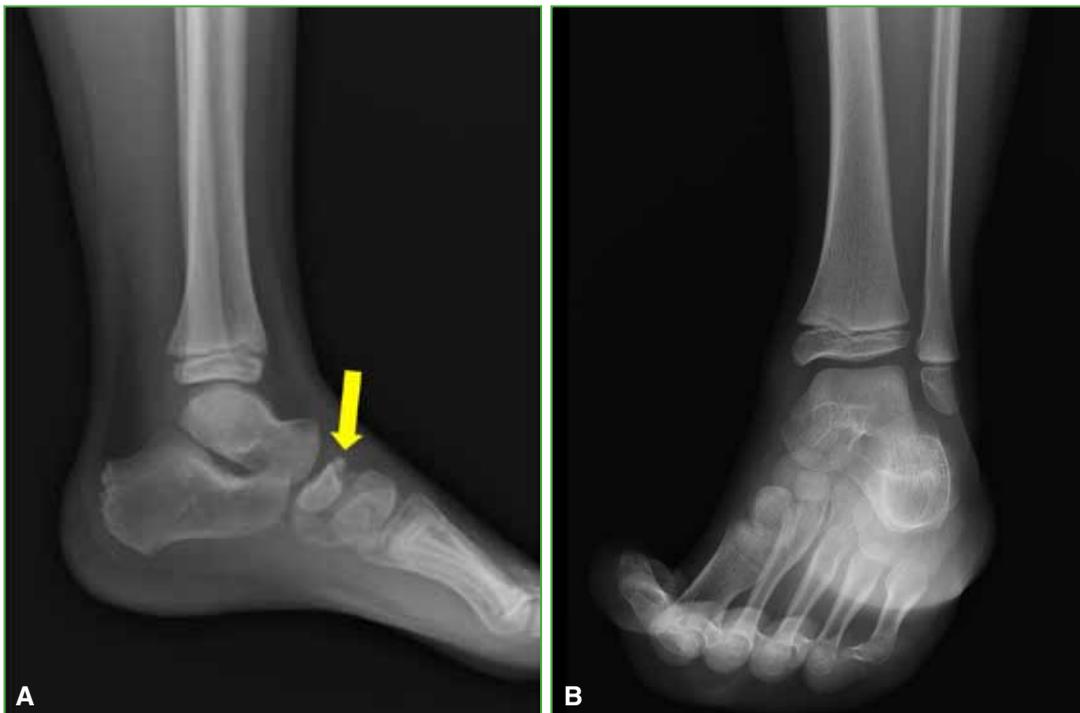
Lateral and oblique X-ray views of the left foot. Navicular morphological changes including fragmentation and sclerosis in its superior sector.
